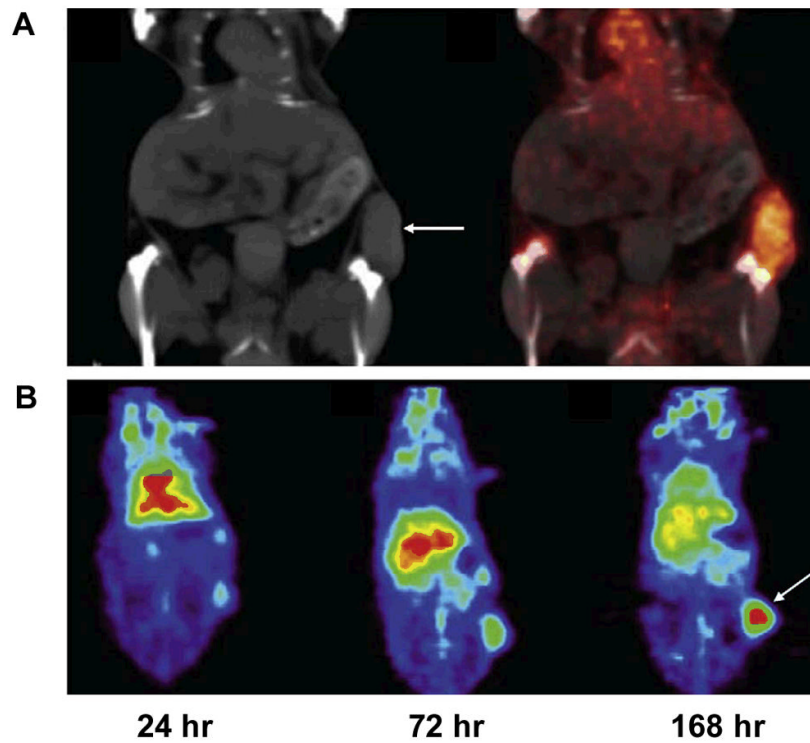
Noninvasive imaging of VEGF expression *in vivo* by ^{89}Zr -labeled VEGF antibody Bevacizumab. A. Coronal CT image (left) with clear subcutaneous localization of SKOV-3 tumor (arrow) and fusion of microPET and CT images (right) (168 h after injection) (arrows indicate SKOV-3 tumors). B. Coronal planes of microPET images at different time points after ^{89}Zr -Bevacizumab injection. Reproduced from reference ⁵² with permission.
